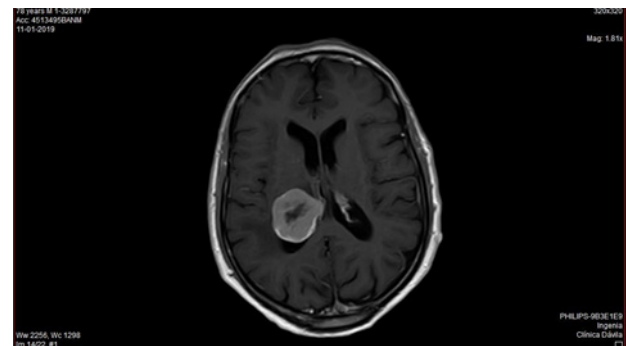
Contrasted MRI depicting a rightsided intraventricular meningioma
